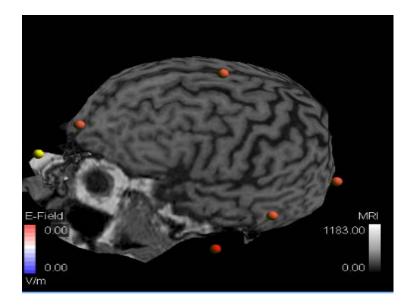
Participant #1 (I.A.) MRI. Lateral left view of the participant's brain, which was used with neuronavigation to locate the DLPFC. Post CVA lesion was not visible at MRI. The participant's CVA was confirmed with written medical referral dated February 2017.
